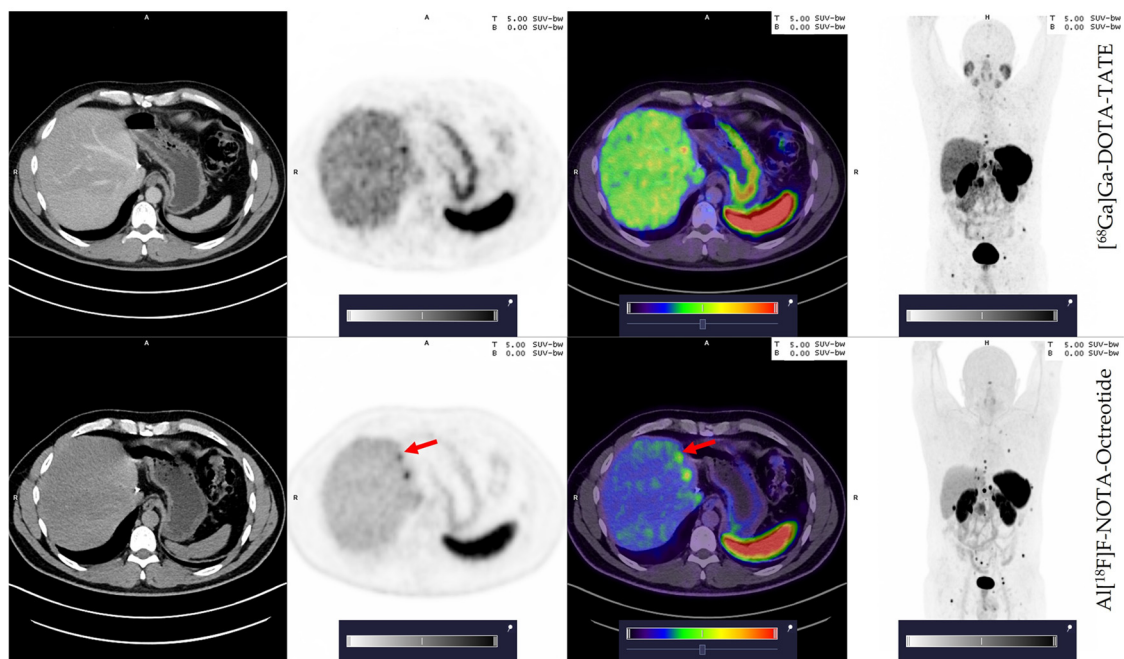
Patient 10; 42 years old, male with an additional small liver lesion (red arrow) detected by $\text{Al}[^{18}\text{F}]\text{F-NOTA-Octreotide}$ (lower row) and not seen with $[^{68}\text{Ga}]\text{Ga-DOTA-TATE}$ (upper row). Colour scale bar representing SUV values ranging from 0.0–5.0.
